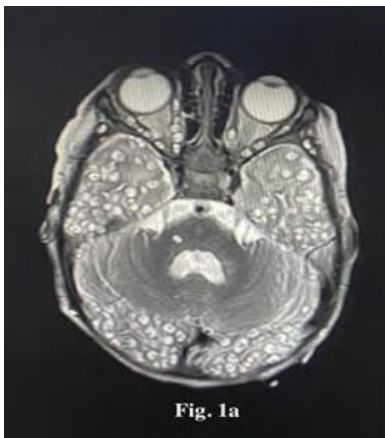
T2 weighted Axial view MRI showing innumerable inflammatory granulomas involving orbit and brain parenchyma
